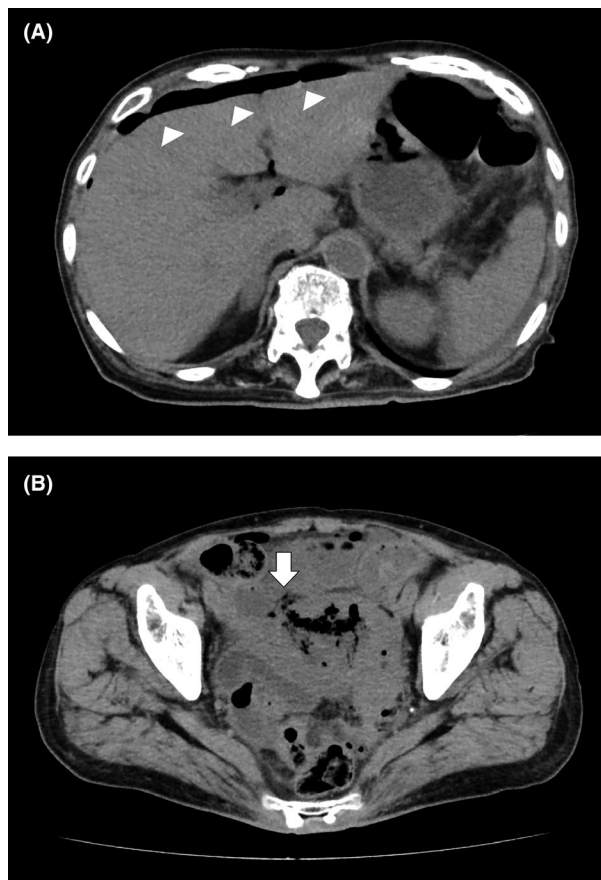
Computed tomography (CT) images of an 83-year-old woman with spontaneous perforation of pyometra. A, CT image shows the presence of a large amount of fluid within the abdominal cavity and free intraperitoneal air (white arrowheads), mostly in the upper abdomen. B, CT image shows a fluid-filled uterus with small air bubbles in the uterus cavity and perforation at the fundus (white arrow) on the right side.
